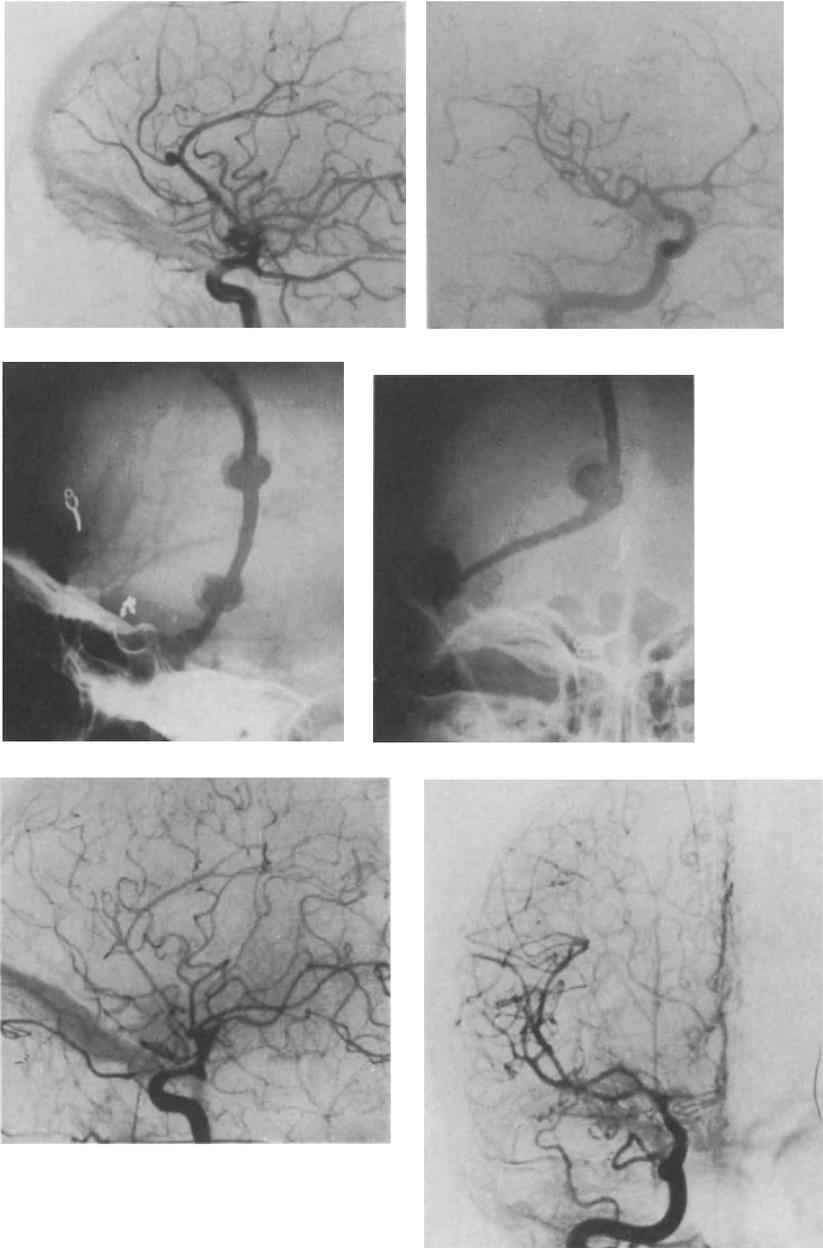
Female 40 years, acute SAH. Multiple aneurysms: ACOA and peric. A. Operation 4. day. Normal course. Preoperative angiograms, postoperative skull X-rays and angiograms
